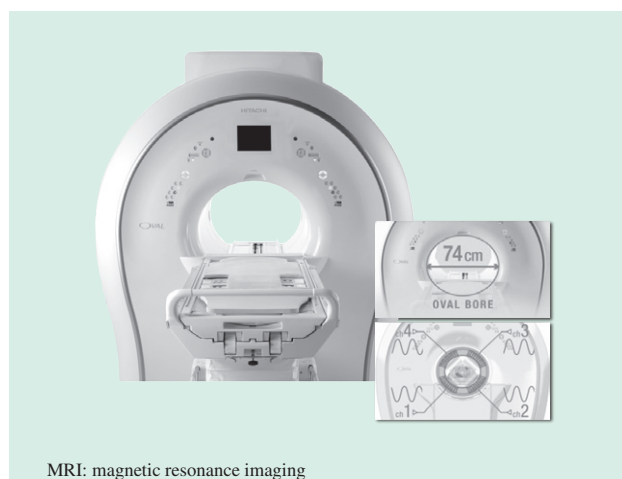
3-T Superconducting MRI System.
